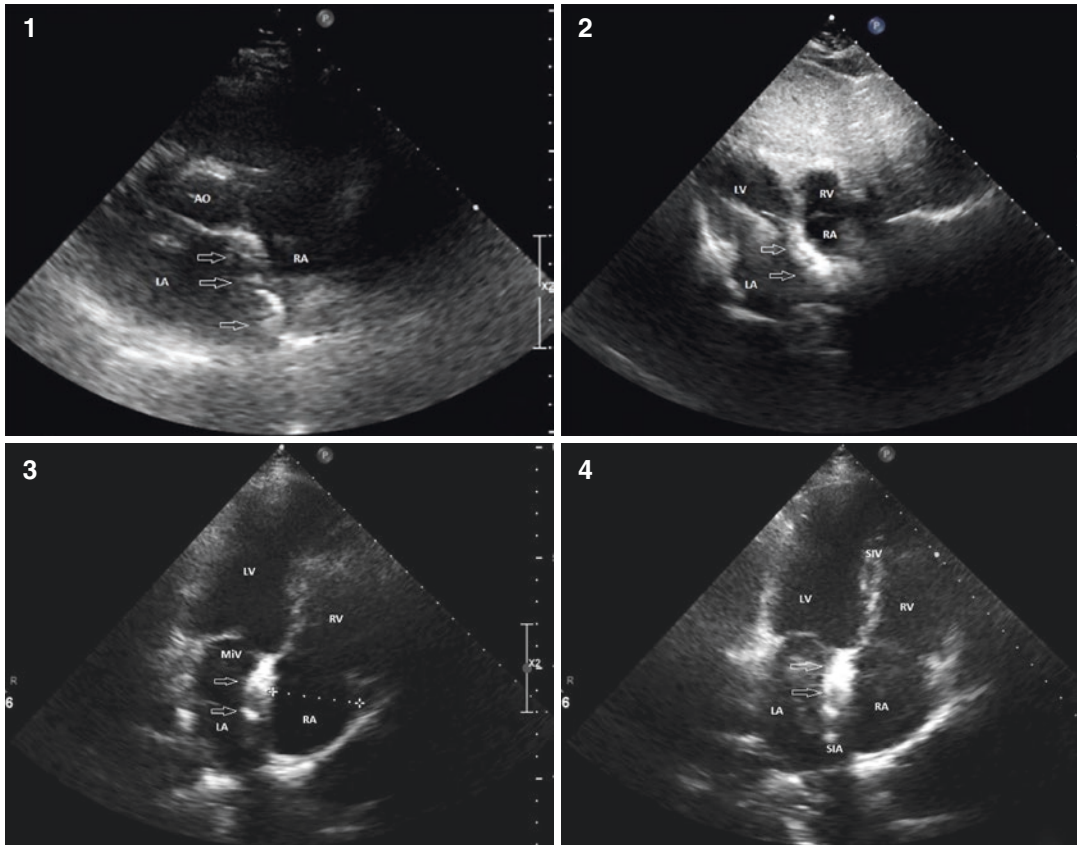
The transthoracic echocardiography views of the Amplatzer system implanted in the atrial septum. (1) Transverse section view (arrow). (2) Sub-xiphoid view (arrow). (3) and (4) Apical 4 chamber view (arrow).
